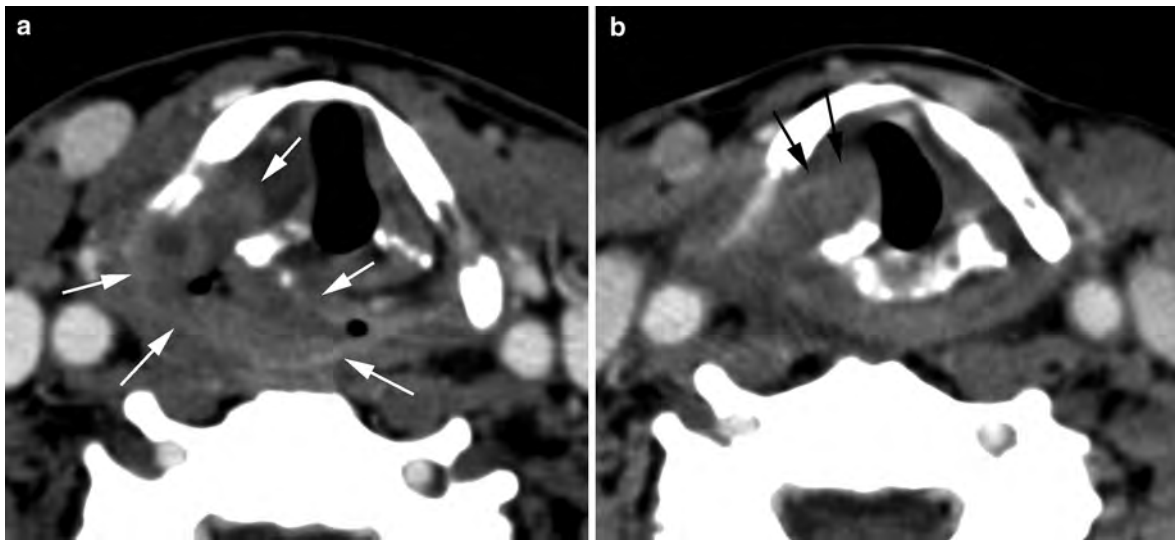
Axial contrast-enhanced CT images pre (a) and post (b) radiation therapy for a large pyriform sinus cancer on the right (arrows in a) show marked decrease of the tumor at the pyriform sinus level with persistent mass in the right true vocal
